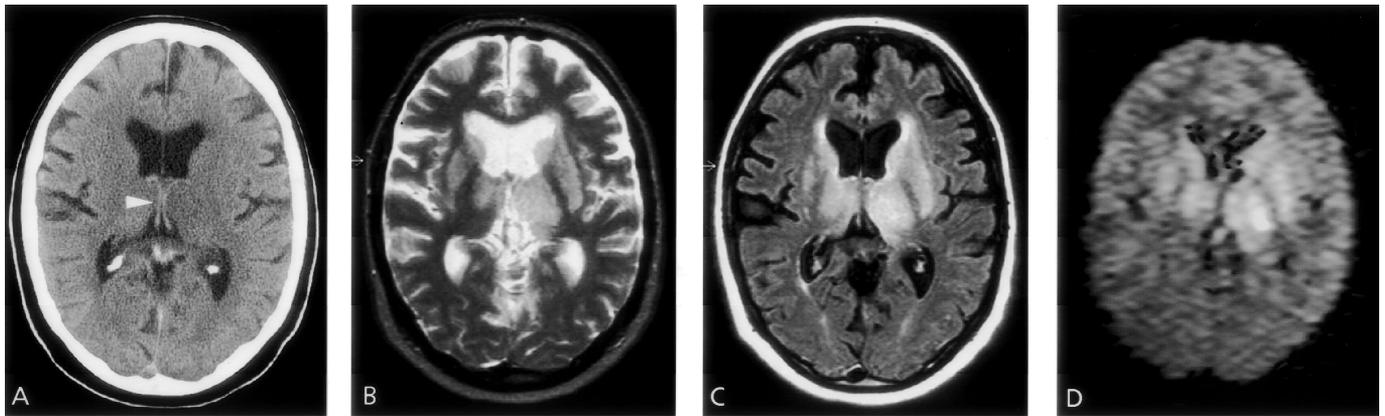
Case 3. (A) Brain CT showing a dense vessel sign in both internal cerebral veins (arrowhead). (B) Axial MRI T2 SE, (C) MRI FLAIR, and (D) MRI DWI showing bilateral hyperintense lesions in the basal ganglia representing edema and venous infarction.
